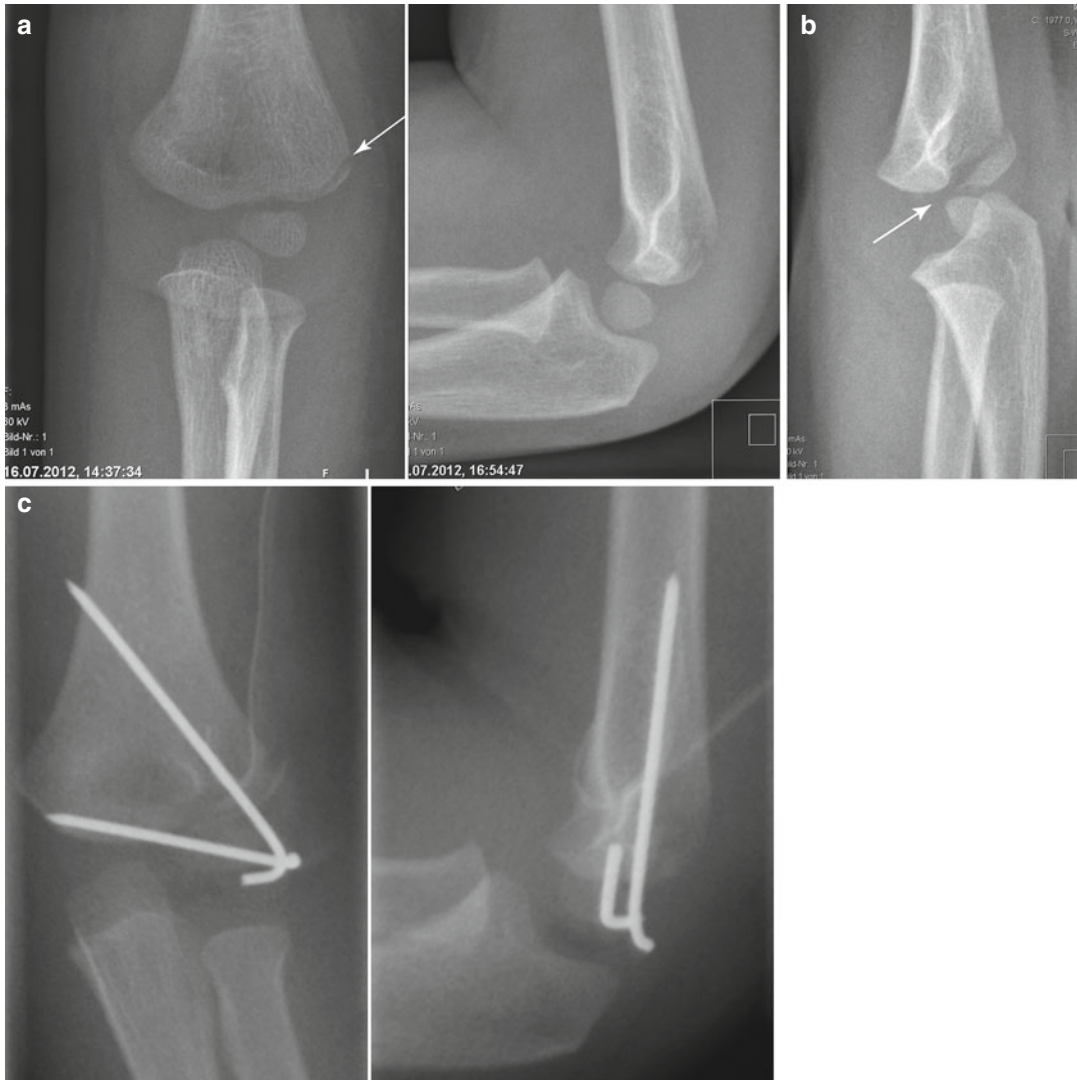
Lateral condyle fracture of the humerus with displacement below 2 mm treated by cast immobilization (a). According to our recommendation after 5 days a cast free x-ray was made and shows a secondary
